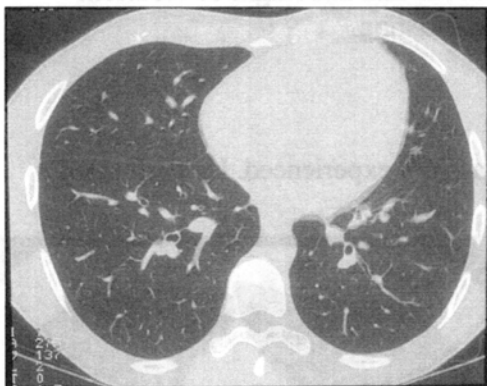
Chest CT, high resolution mode (Case 3).
